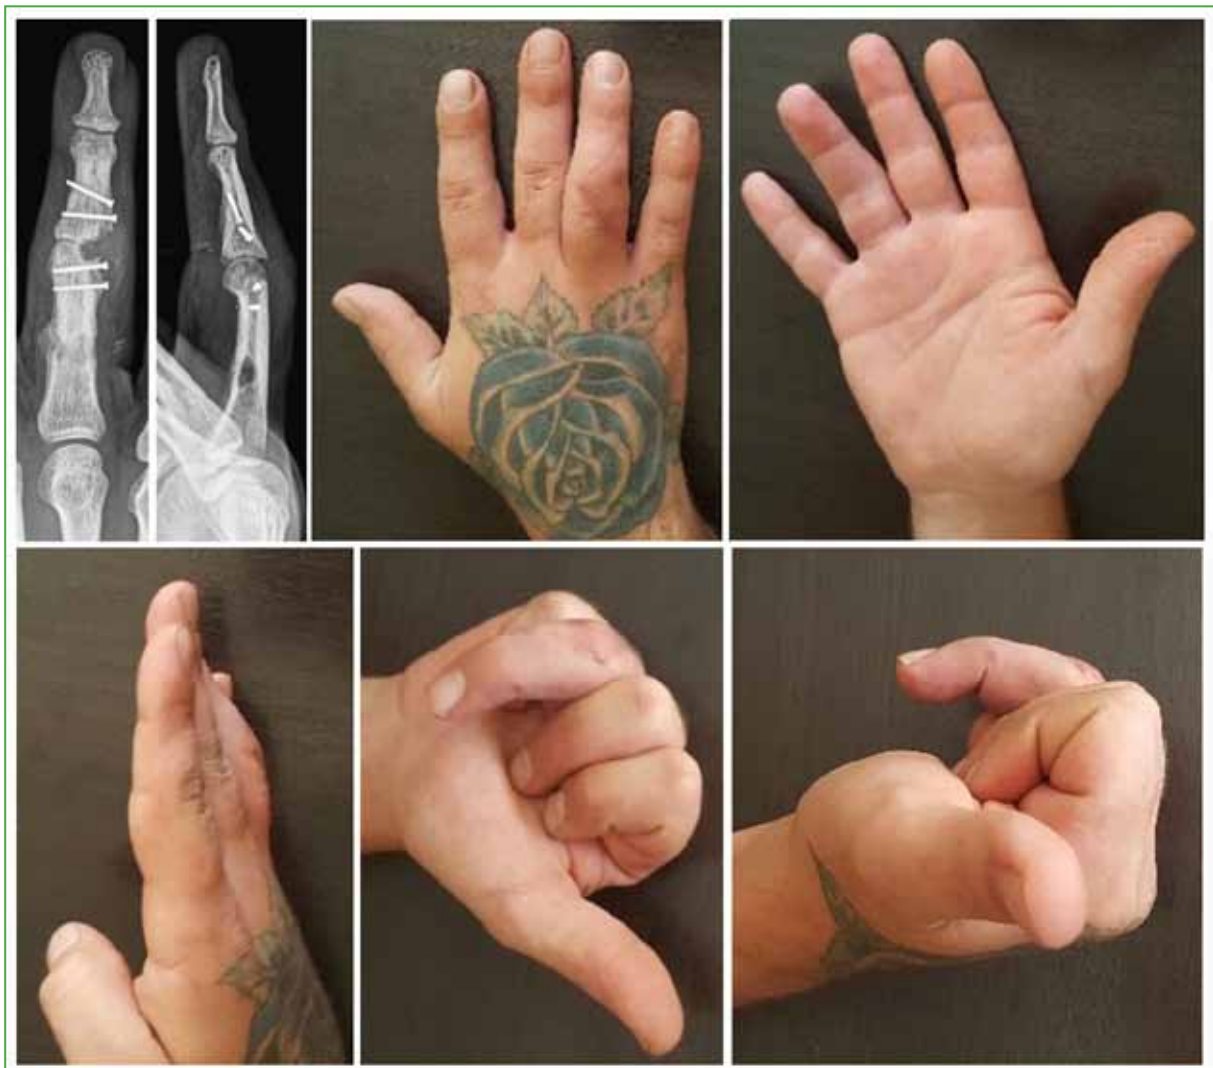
Radiographs and clinical evolution at the time of discharge.
